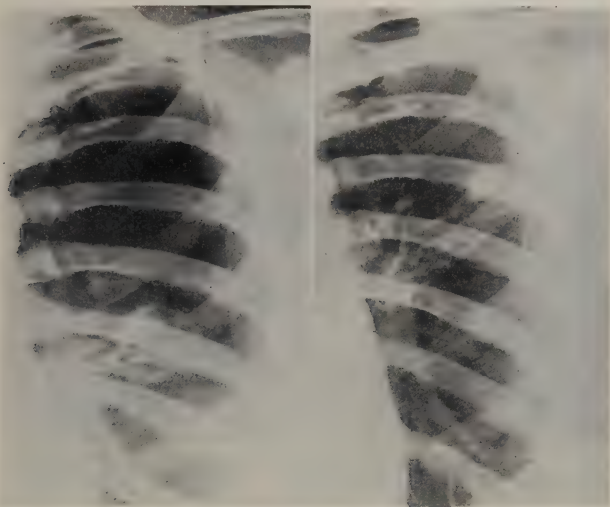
(Case 9). A (Left). Roentgenogram, taken on April 27, 1943, following a pneumothorax.
